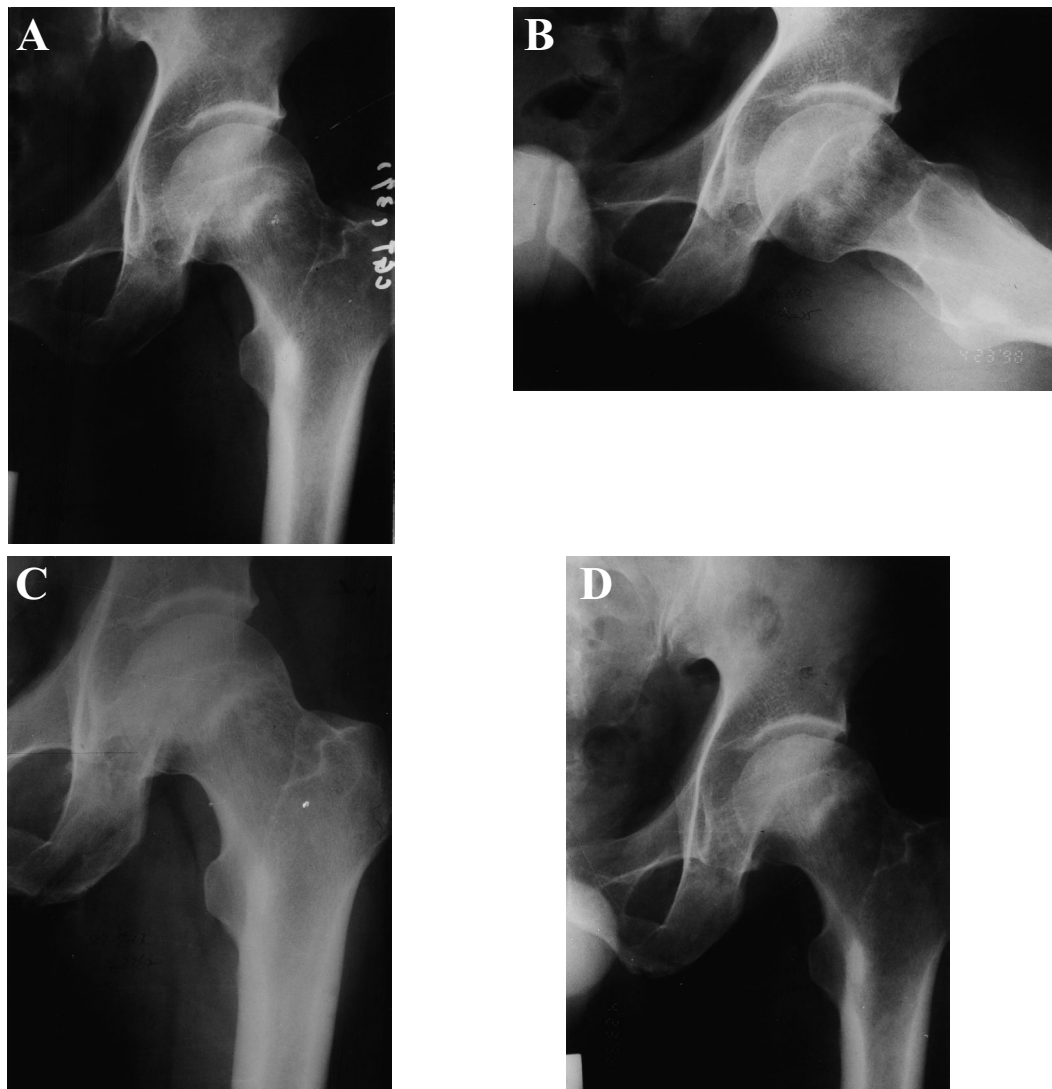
Delayed collapse of the osteonecrotic femoral head. (A) ARCO stage IIC and Ohzono type IIIB on initial radiograph. (B) Frog lateral view of the same hip. (C) Two years later, the femoral head had remained spherical without collapse. (D) The hip eventually collapsed 4 years and 3 months after the first visit.
